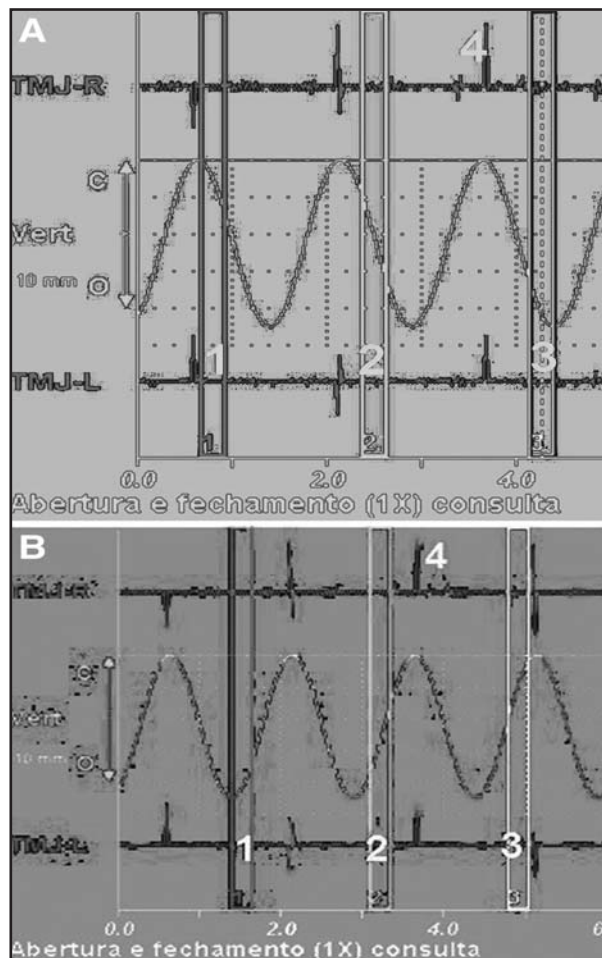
Electrosonography recording. Numbers 1, 2 and 3 show the positions of the movement cycles (A – Opening, B – Closing) at which joint vibrations were analyzed. Number 4 indicates the position equivalent to occlusal contact in mouth closing at maximum intercuspation.
